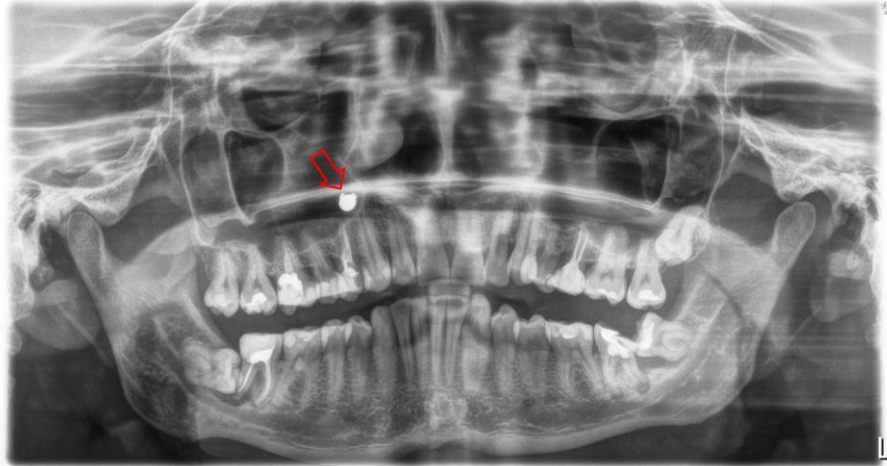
Orthopantomogram.
